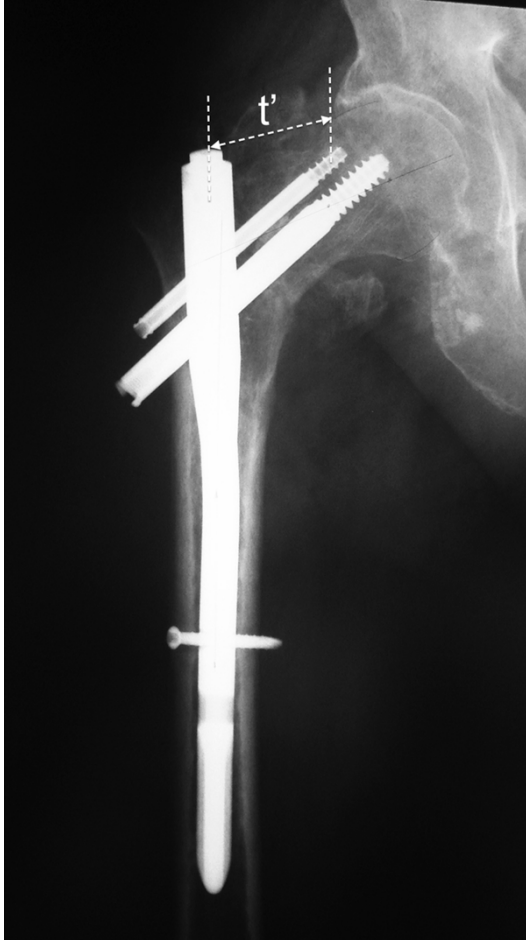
Neck shortening was calculated by measuring distance (t') in early and late postoperative X-rays. Distance (t') between PFN and superior edge of the femoral head is seen on late postoperative roentgenogram.
